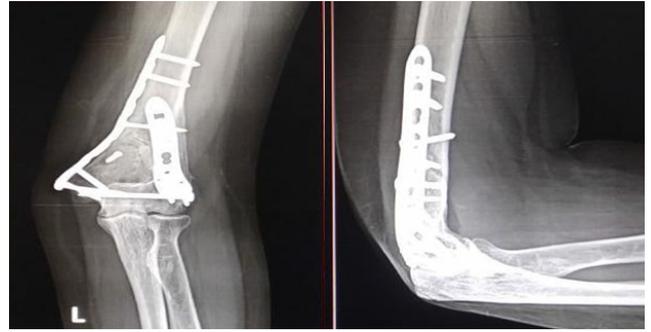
Follow-up radiograph at 6 months also showing bone union
